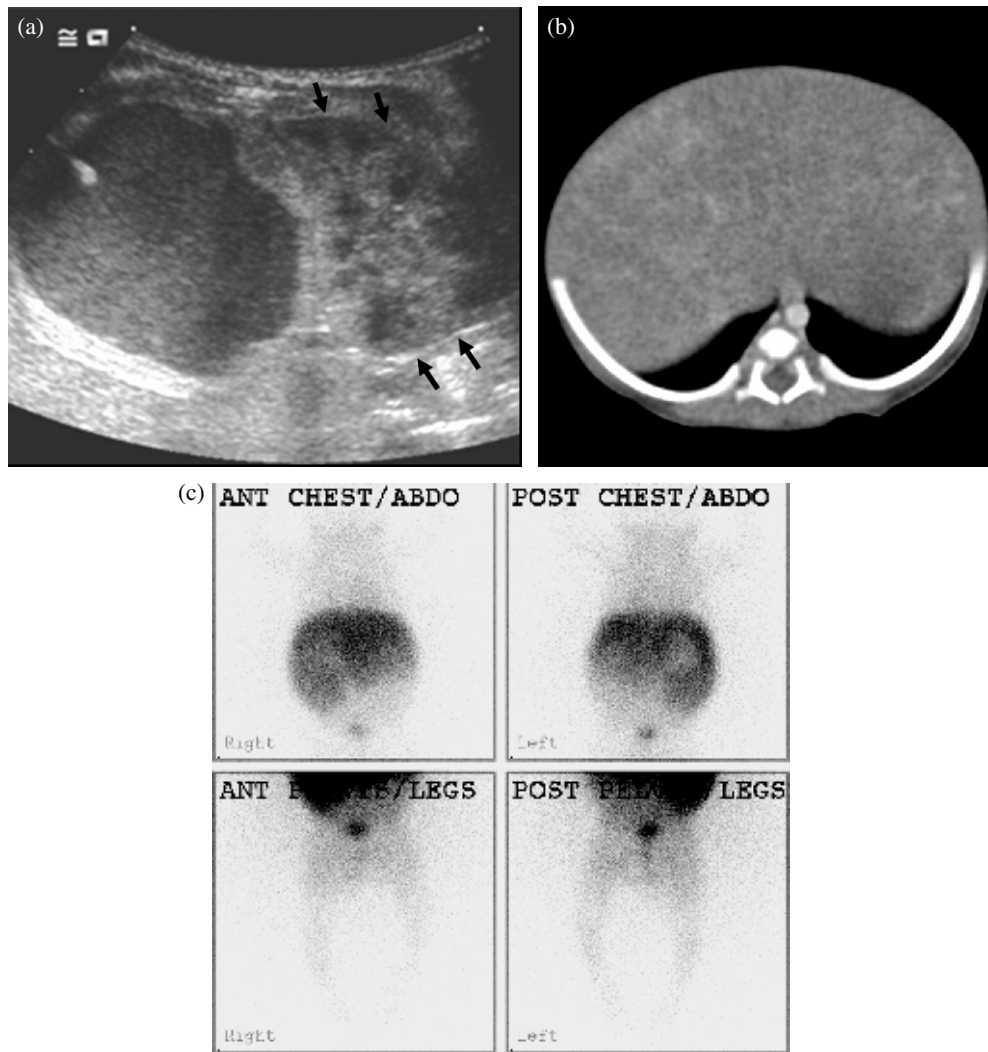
Imaging of a 2-week-old girl with an antenatally diagnosed right supra-renal lesion. (a). Longitudinal section of abdominal US reveals a hypoechoic, almost cystic, lesion (neonatal NBL) in the right supra-renal area which displaces the right kidney inferiorly (arrows). (b) Axial CT section of the abdomen demonstrates heterogeneity and enlargement of the liver that represent diffuse infiltration (stage 4S). (c) Intense MIBG tracer uptake in the liver is noted.
